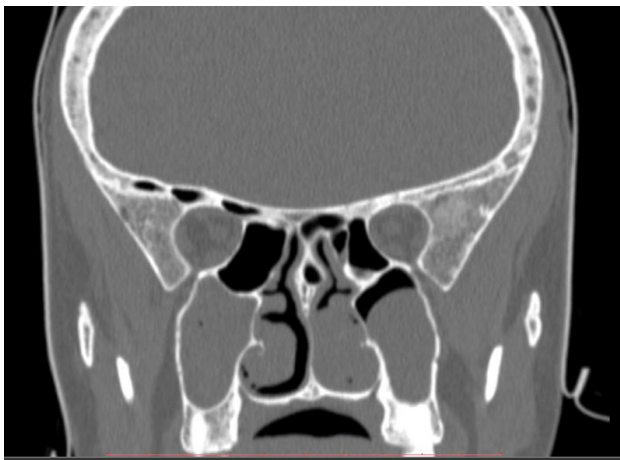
Coronal reformatted CT of the paranasal sinus showing an isodense lesion completely obliterating the right antrum. A similar lesion is noted in the left antrum with a superior convex margin. Enlarged inferior nasal turbinates are also noted.
